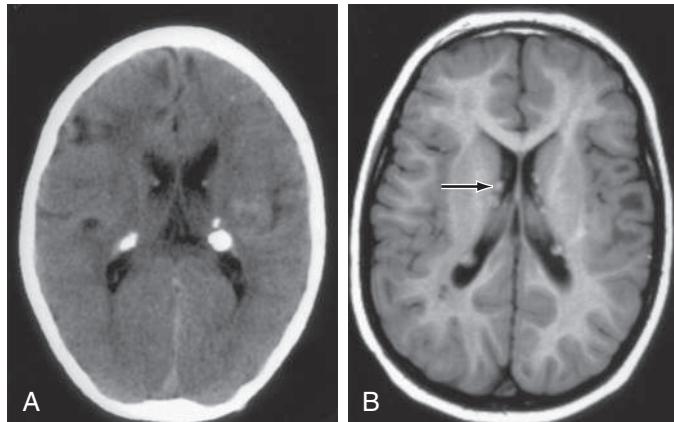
Tuberous sclerosis. A, CT scan with subependymal calcifications characteristic of tuberous sclerosis. B, The MRI demonstrates multiple subependymal nodules in the same patient (arrow). Parenchymal tubers are also visible on both the CT and the MRI scan as low-density areas in the brain parenchyma.
